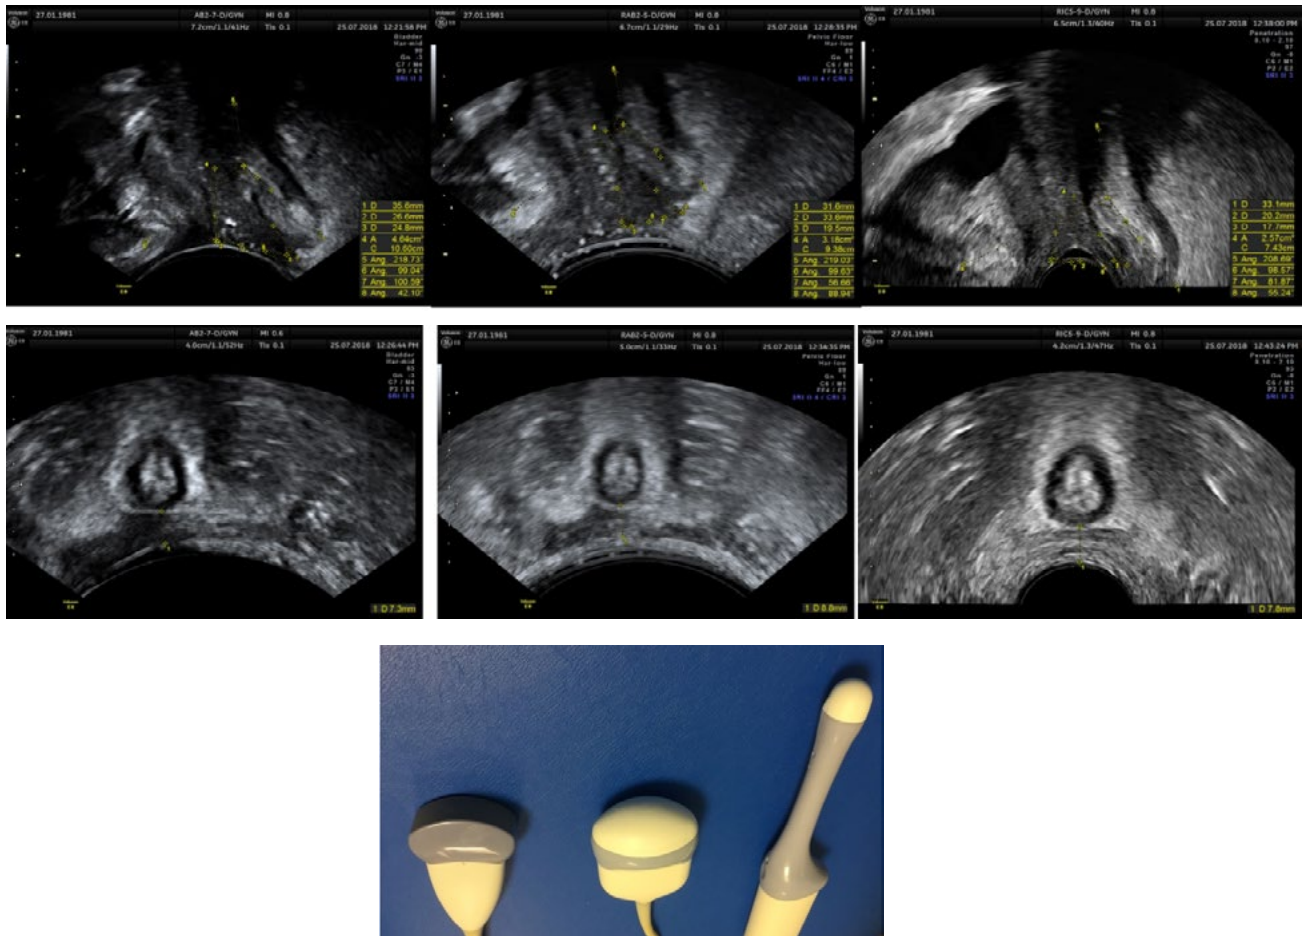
Pelvic floor ultrasound in 2D. The top row of images are mid-sagittal, the 2nd row of images are coronal angled downwards towards the anal canal. The second image shows in order the probes with which these images were acquired: 7 MHz (AB27D); 5 MHz (RAB25D); 9 MHz (RIC50D)
